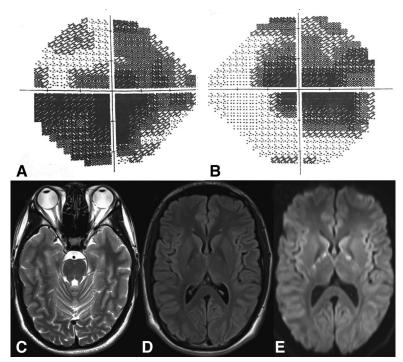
Case 4. Humphrey visual field 24-2 demonstrating central scotomas breaking out infratemporally and supranasally in the left eye (\mathbf{A}) and temporally in the right eye (\mathbf{B}). (\mathbf{C}) T2 axial MRI image showing normal appearing orbits. (\mathbf{D}) Axial MRI FLAIR image showing foci of hyperintensity in the bilateral posterior limb of the internal capsule. This was associated with increased signal on isotropic diffusion-weighted imaging (\mathbf{E}) confirmed by decreased signal on apparent diffusion coefficient imaging, consistent with abnormal diffusion restriction in this region.
